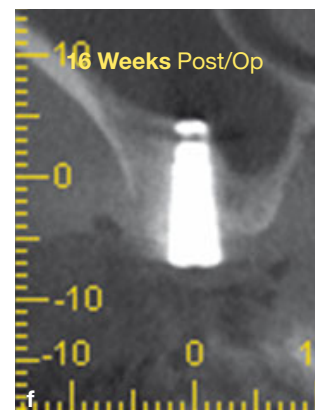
CBCT (coronal view) of the same patient 16 weeks following the procedure, demonstrating the formation of bone in the tent.
